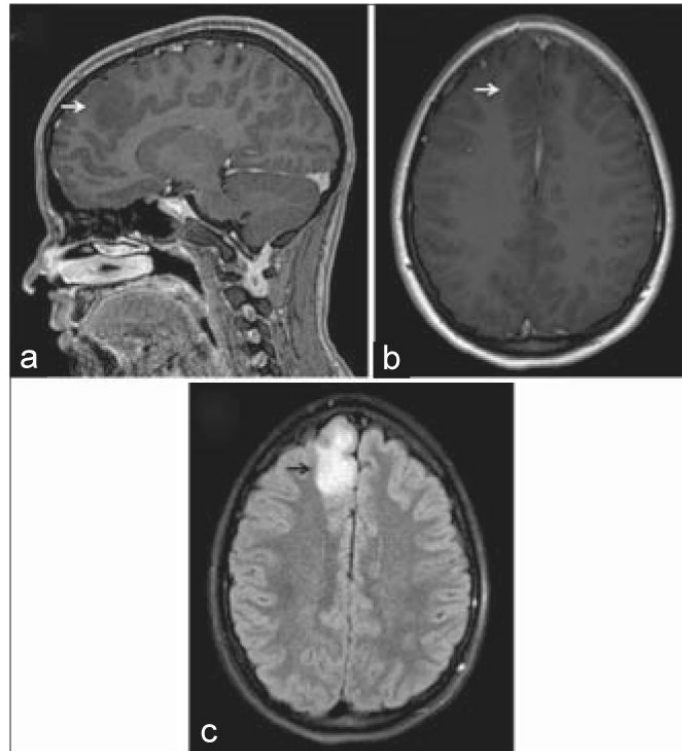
Radiographic characteristics of diffuse astrocytoma. (a) Sagittal and (b) axial views of a T1-weighted magnetic resonance imaging (MRI) after contrast administration, demonstrating a non-enhancing hypointense mass (white arrows) abutting the falx. (c) On a T2-weighted MRI, there was significant associated fluid-attenuated inversion recovery edema (black arrow)
